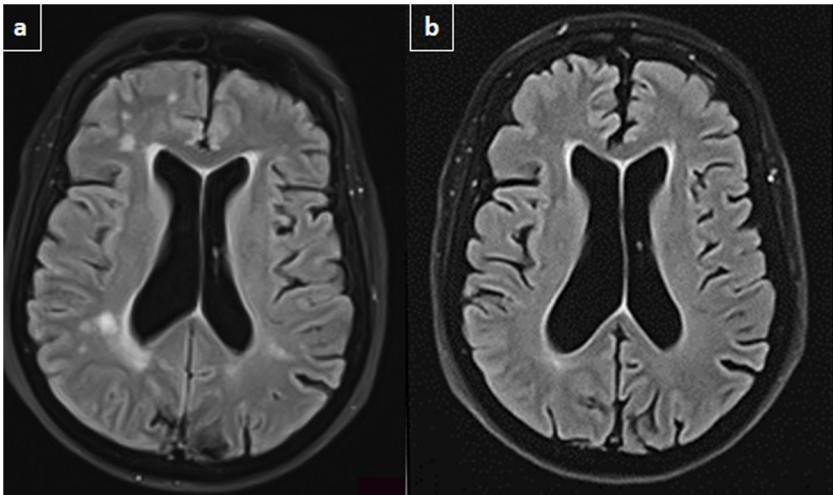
Axial FLAIR-T2 images showing initial white matter hyperintensities (a) and their disappearance after treatment (b).
